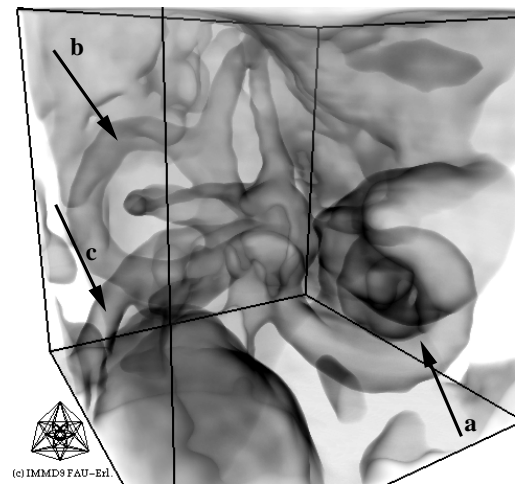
Structures of the inner ear within CT.
